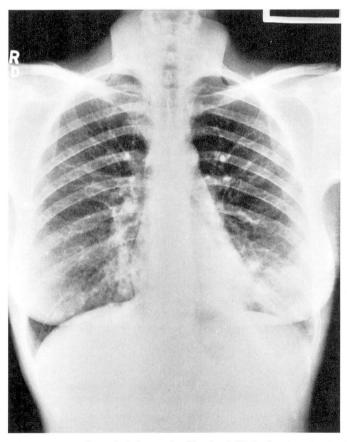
Chest roentgenogram on first admission to the Cleveland Clinic showing alveolar infiltrate at the left base and some prominence of the interstitial markings at the right base.
